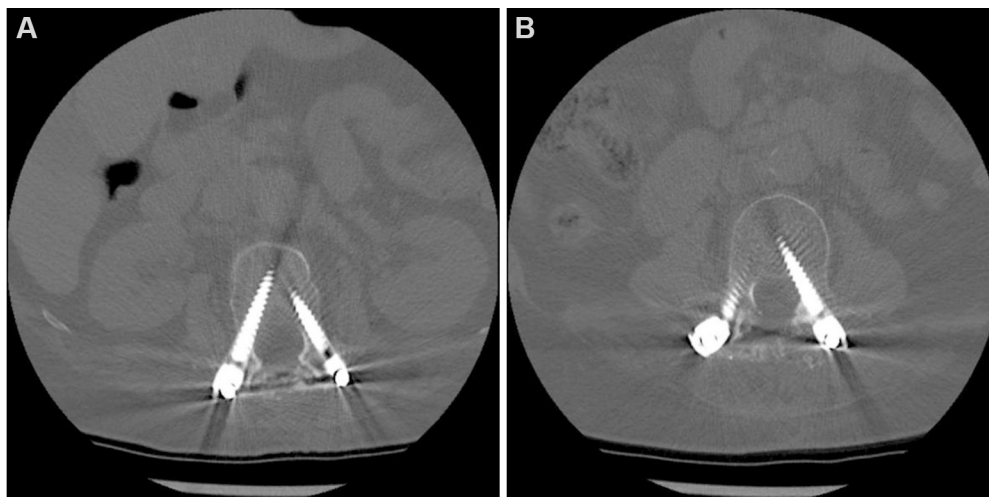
Axial CT scan showing: (A) Grade A on the left pedicle screw; and (B) Grade B on the right pedicle screw. CT: Computed tomography.
